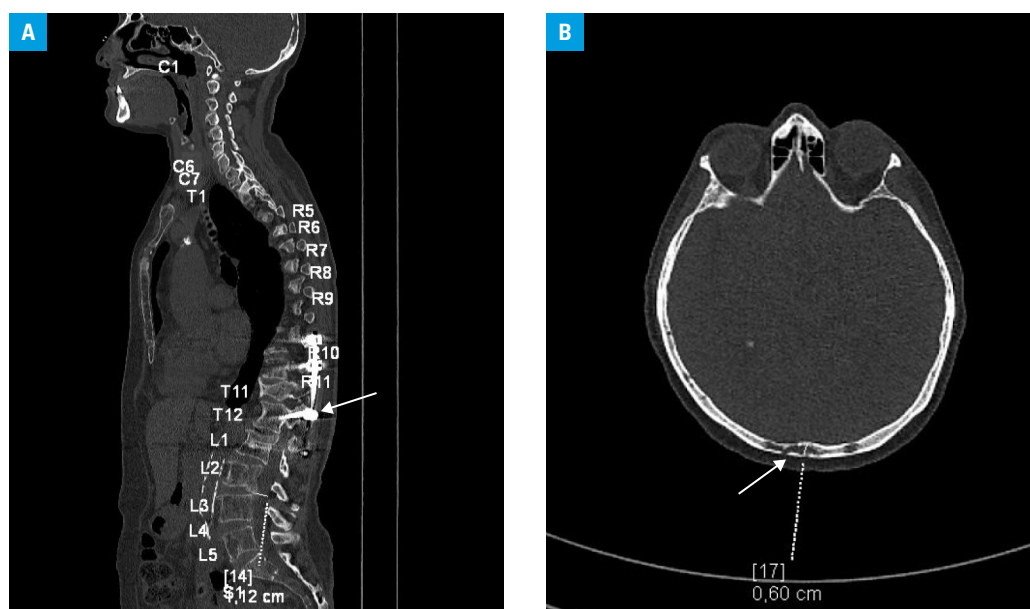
A – computed tomography of the whole body (polytrauma protocol) performed in December 2019, showing a history of a burst fracture of the T12 vertebral body in the course of chondrosarcoma; the lesions were not radically removed. Posterior stabilization of the spine with stabilizing rods and transpedicular screws (arrow), wedge-shaped decrease at the height of the T5 and T7 vertebral bodies (as a result of fractures) as well as numerous osteolytic lesions due to multiple myeloma are visible. B – computed tomography of the head (transverse plane) visualizing numerous osteolytic lesions of various sizes in the bones of the skull; the largest lesion (29 × 9 mm) is localized in the occipital bone (arrow)
